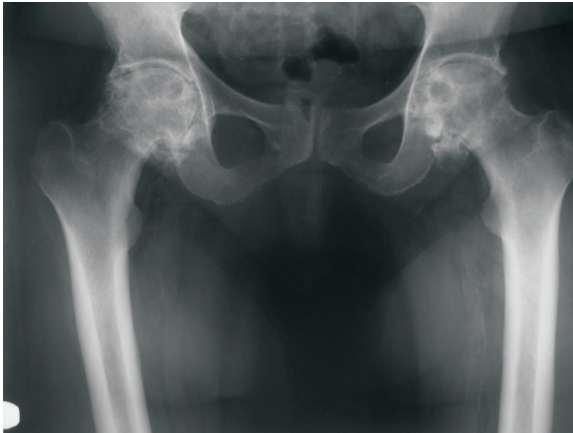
Antero-posterior X-ray of the pelvis and both hips showing advanced bilateral hip osteoarthritis with the presence of classical radiographic findings, such as joint space narrowing, subchondral sclerosis, osteophytes, and subchondral cysts.
